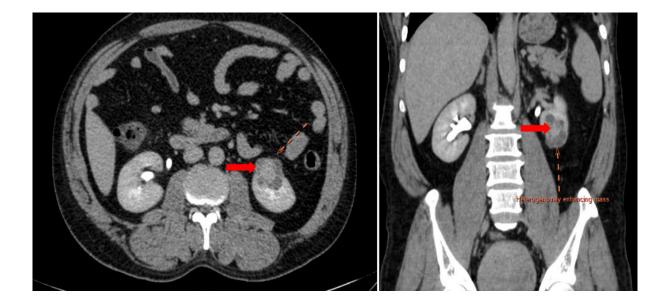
Contrast enhanced CT-KUB showing a well defined, solitary, partially exophytic, multicystic with solid component, heterogeneously enhancing left lower pole renal mass.
